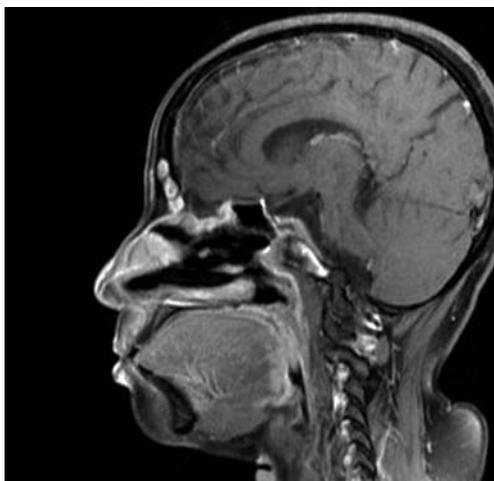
MRI orbit, PNS and brain were done 2 weeks after the first stage of debridement showing residual lesion extending superiorly to erode the floor and medial wall of left orbit infiltrating the extraconal compartment of left orbit resulting in orbital proptosis
